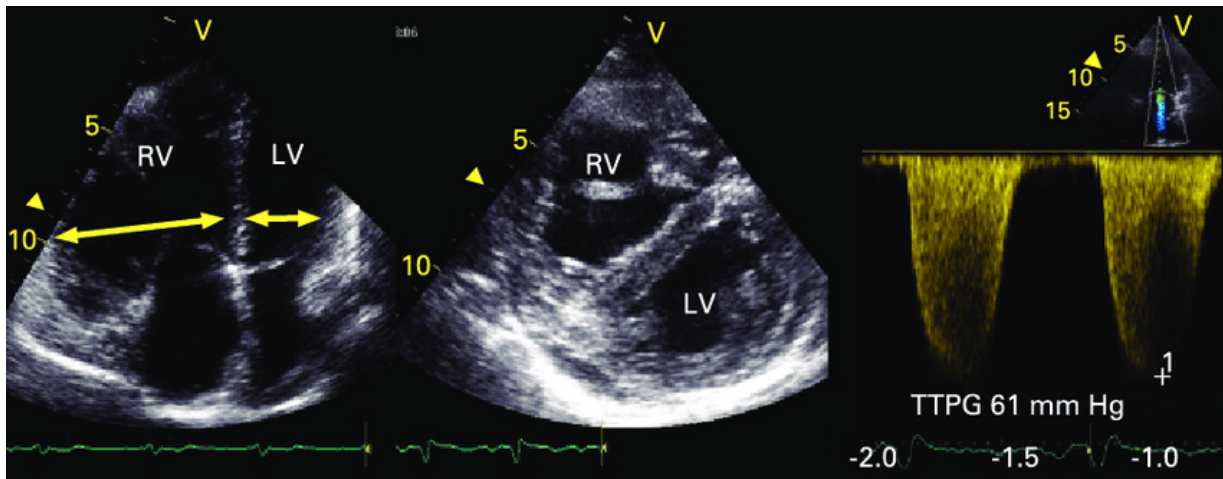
Images of Right Ventricle Expansion in Pulmonary Embolism from A4 and PSSA view. A: The increase in the diameter of the RV compared to the LV in terms of A4 view. B: The increase in the diameter of the RV compared to the LV in terms of PSSA view. RV: right ventricle, LV: left ventricle, A4: apical four chamber, PSSA: parasternal short axis
